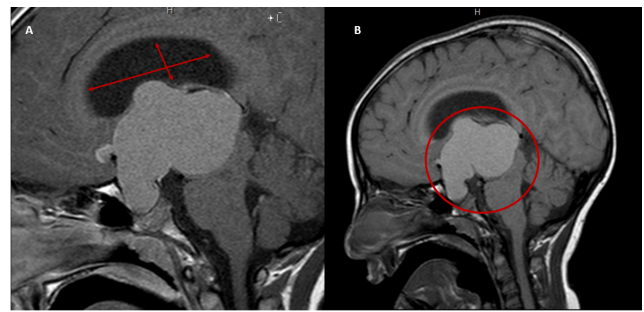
Presurgical sagittal views of MRI brain with contrast demonstrating a lobulated homogeneous mass in the suprasellar region. Mass appears moderately hyperintense on T1, measuring 47 x 64 mm (right panel). Post contrast view (left panel) demonstrates a thin enhancing rim but not significant enhancement of the mass, suggestive of a cystic structure filled with high protein content fluid. Obstructive hydrocephalus is noted.
